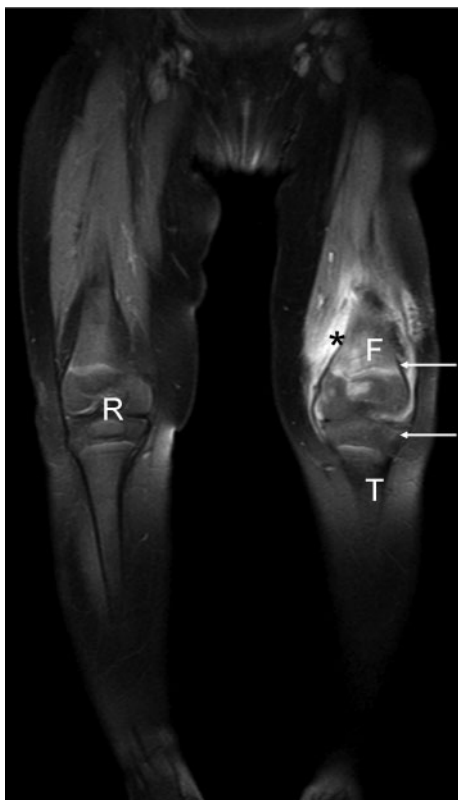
Coronal MRI (T1 TSE) with contrast medium (gadolinium DTPA) of both lower extremities after 30 days. Compared with the completely normal right knee (R), synovial (asterisk) and osseous (arrows) enhancement of the left knee is seen. F, Femur; T, tibia.
